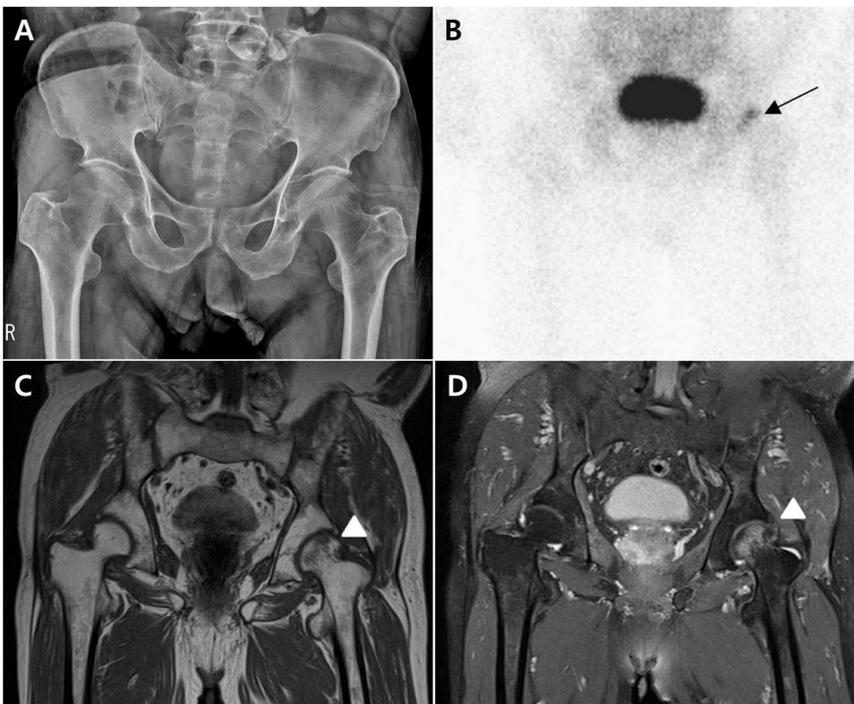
(A) Hip radiography revealed no definite abnormality. (B) Whole body bone scan showed hot spot at the left femur head (arrow). (C, D) On MRI of the left hip, a diffuse bone marrow edema pattern (arrow head) is seen, with low signal intensity on T1-weighted imaging (C) and high signal intensity on T2-weighted imaging (D).
